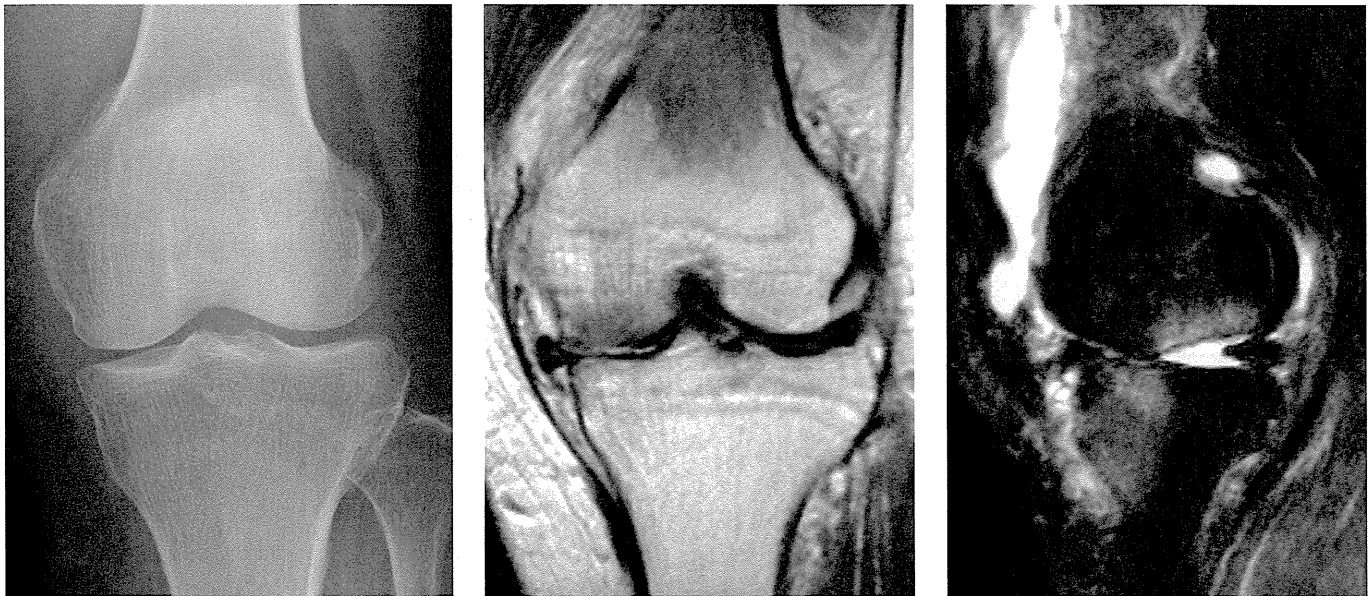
A. An AP radiograph from a 65-year-old woman, who had had sudden onset of left knee pain 10 weeks previously, showing no lesions in the medial femoral condyle. The patient was classified as being at stage 1 of SONK and Kellgren-Lawrence Grade 1.
